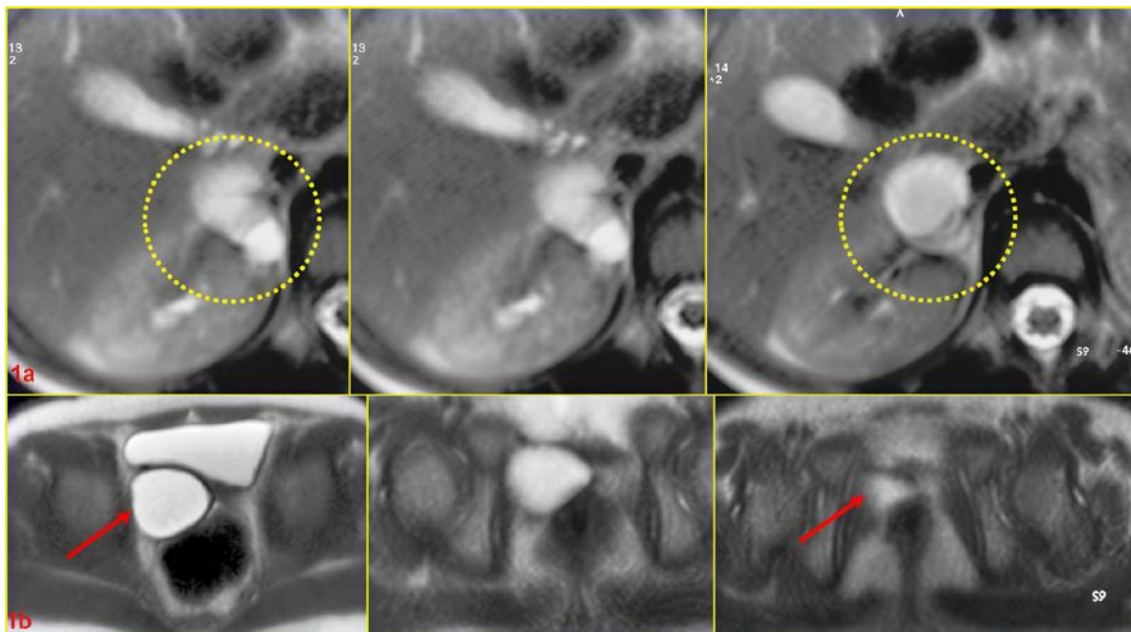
a-b Axial T2-weighted images (a), at the level of the right kidney (Circle), (b), at the level of the urinary bladder (Arrow) which show a dilated remnant of the mesonephric duct
